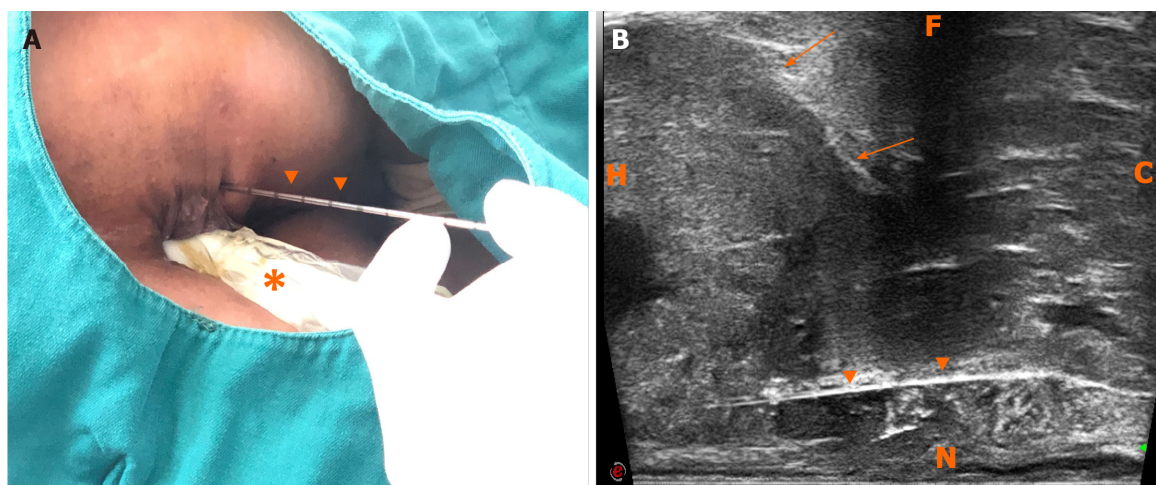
Freehand transperineal biopsy of the rectal subepithelial mass guided by endorectal ultrasound. A: The patient in left lateral decubitus, and the freehand transperineal biopsy was performed, guided by endorectal ultrasound (ERUS); B: Longitudinal sectional image of transperineal core needle biopsy guided by ERUS obtained with the linear probe of TRT33. H: Head; C: Caudal; N: Near field; F: Far field; arrows: Rectal stromal tumor; triangular arrowheads: Core needle; asterisk: TRT33 probe.
